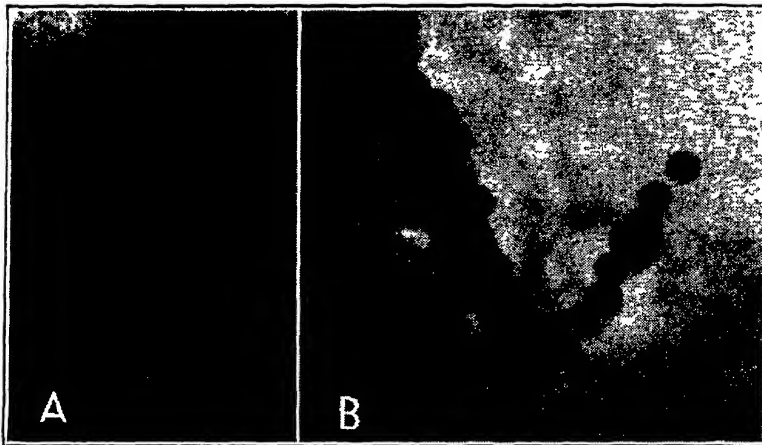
Appendiceal area in *A*, spine roentgenogram, and *B*, with pressure applied under fluoroscopy. (Earl: Jour. Am. Med. Assoc.)
